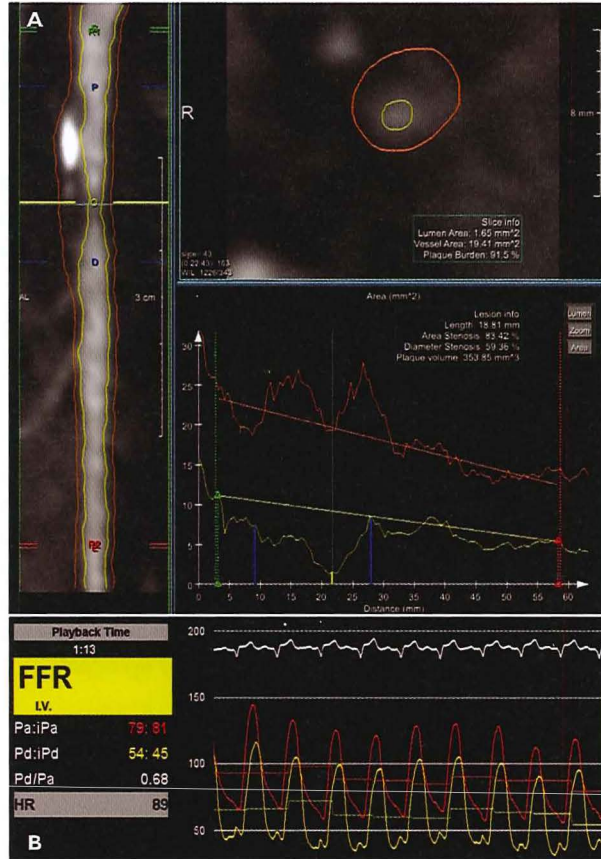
Quantitative CT coronary angiography (CTCA) and fractional flow reserve (FFR) measurement in a moderate coronary lesion.
